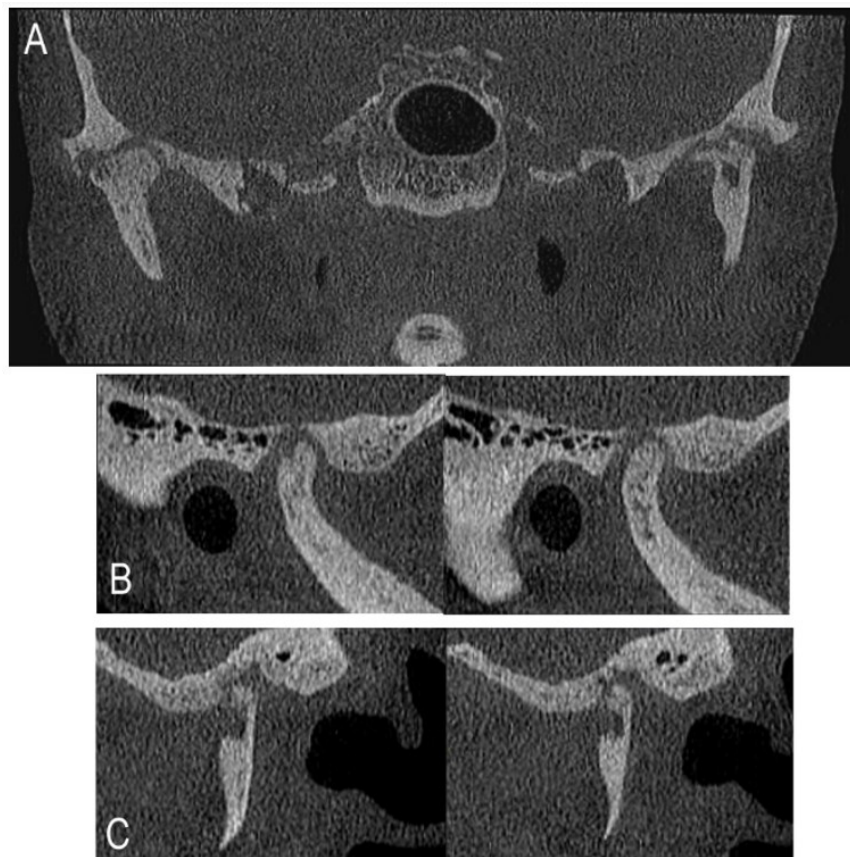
A: Computed tomography showing the condition of the condyles bilaterally. B: Erosion of the right condyle with solution of discontinuity of the cortical bone, with probable dural communication. C: Computed tomography showing bone resorption in the left condyle.
